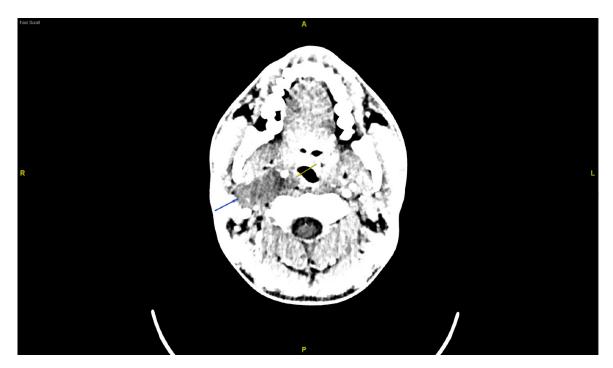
CT scan showing large cystic lesion in the carotid space
